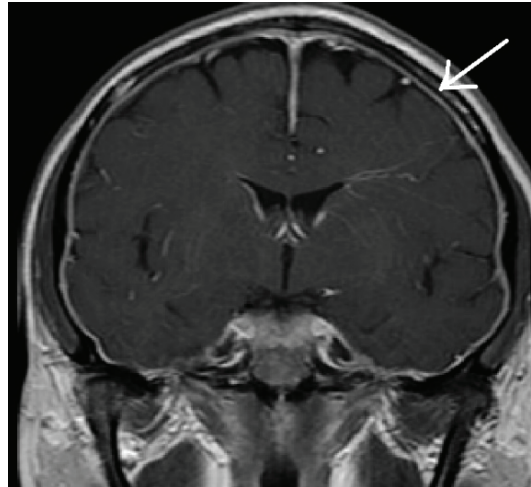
T-1 weighted coronal MR image with gadolinium of patient 3 at the initial headache period showing diffuse pachymeningeal enhancement on behalf of intracranial hypotension
